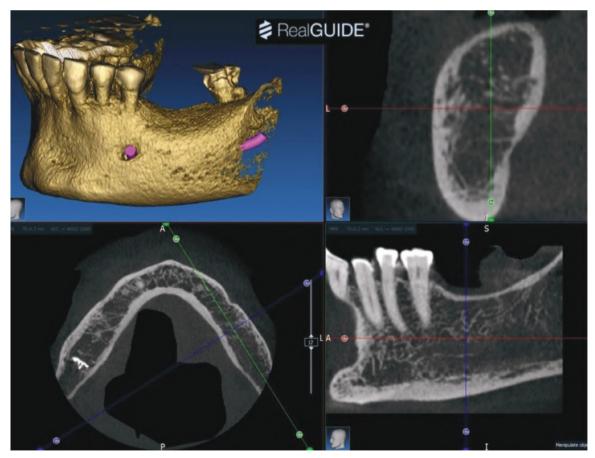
CBCT for diagnostic purposes.
